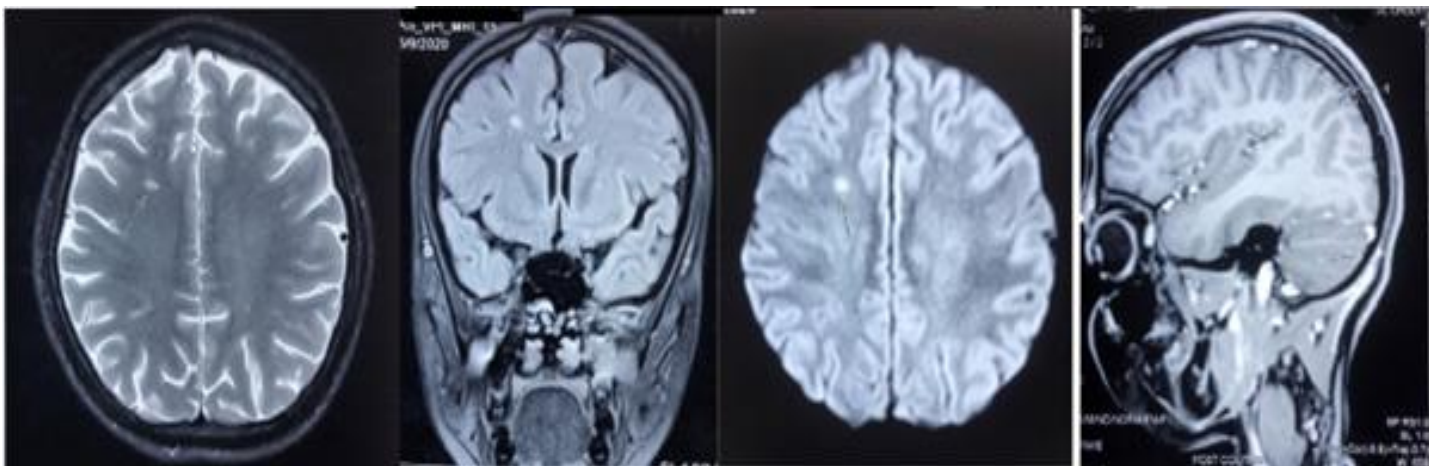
T2, FLAIR, diffusion and T1-C images showing T2 and FLAIR hypertintense foci with no diffusion restriction noted in frontal subcortical region and bilateral centrum semiovale with contrast enhancement of the cerebellar lesion
